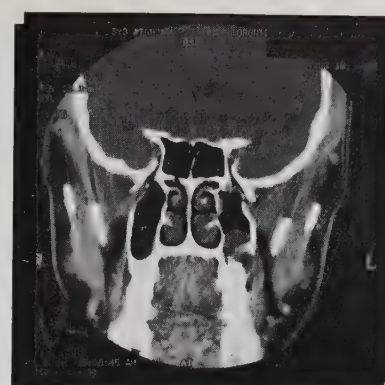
Coronal CT scan shows the expansion of the tumor into the posterior part of the sinus and the lateral destruction of bone. Also seen is a mucus retention cyst.
